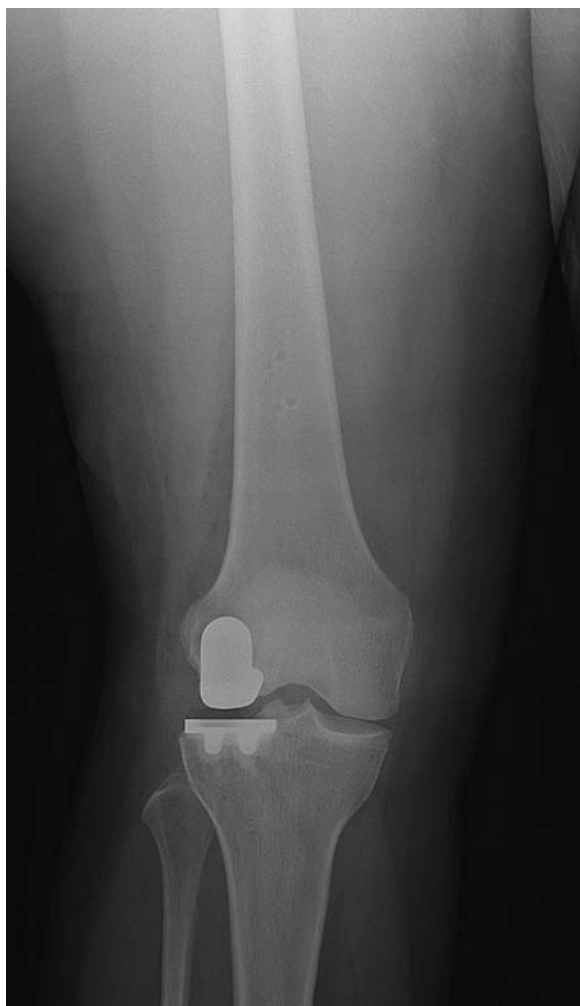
A right knee postoperative anteroposterior radiograph of a 56-year-old female following lateral robotic unicompartmental arthroplasty.
